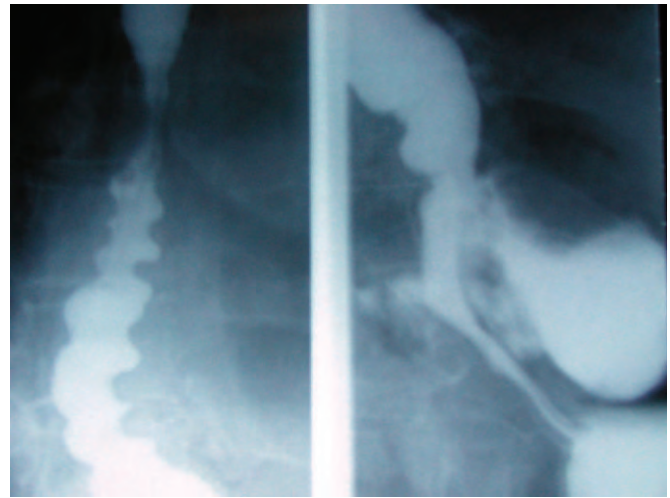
Roentgenographic study using water-soluble contrast material in a patient with a perforation of the esophagus. The patient is placed in the lateral decubitus position with the left side up to allow complete filling of the esophagus and demonstration of the defect.
